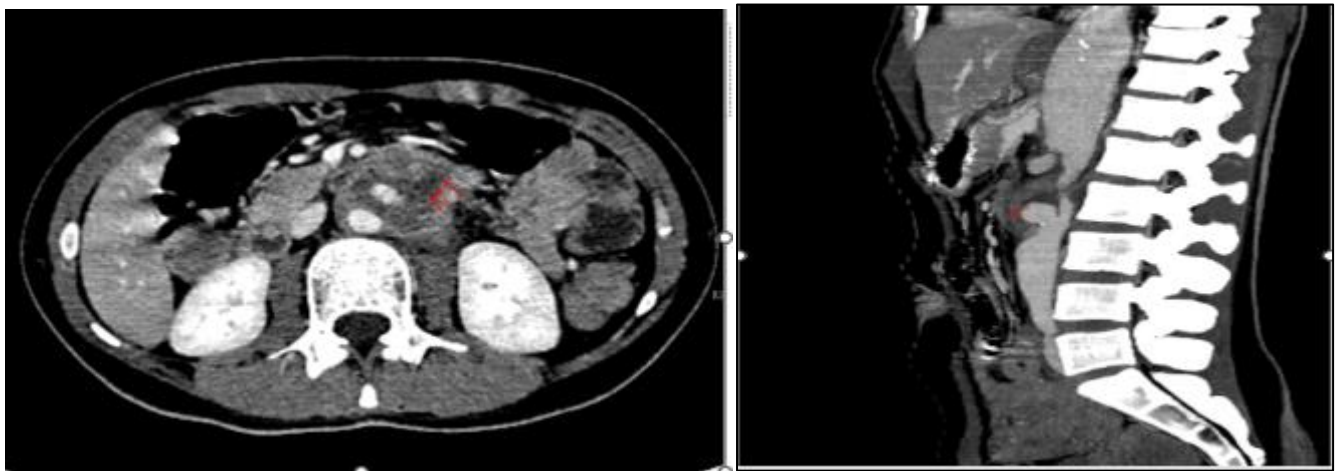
CT images showing inflammatory aortitis complicated by infrarenal pseudoaneurysms, one of which has formed a fistula with the duodenum
